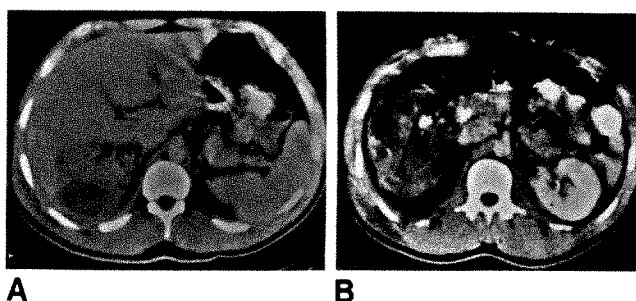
A and B, CT scans show heterogeneous collection in subhepatic space extending to level of upper pole of right kidney. Stippled gas collection within complex mass contains a focus of calcification (arrow).
